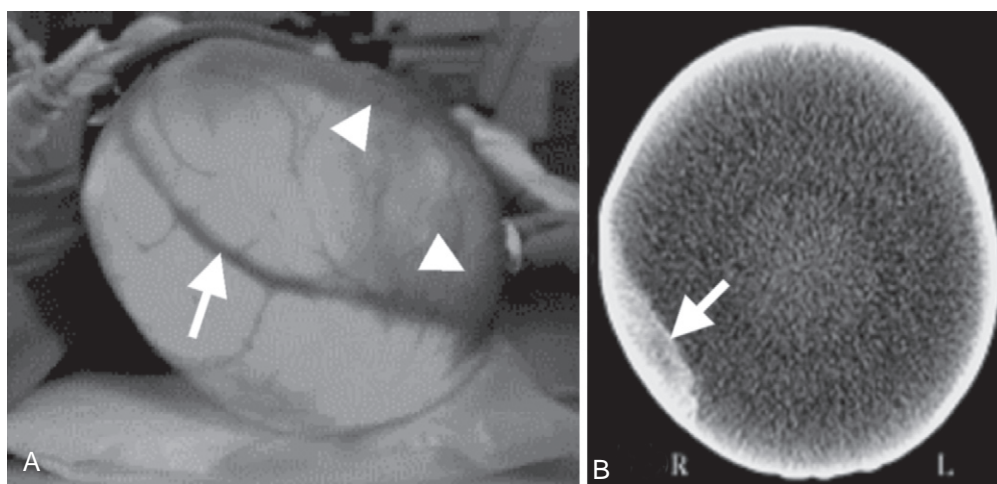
Two-day-old girl with hydranencephaly. A, Transcranial illumination showing the superior sagittal sinus (arrow) and a scant amount of right inferior temporal and occipital cortex (arrowheads). B, Head computed tomographic scan shortly after birth revealing a scant amount of right cerebral cortex posteriorly (arrow). The cerebral hemispheres are replaced almost entirely by cerebrospinal fluid.
